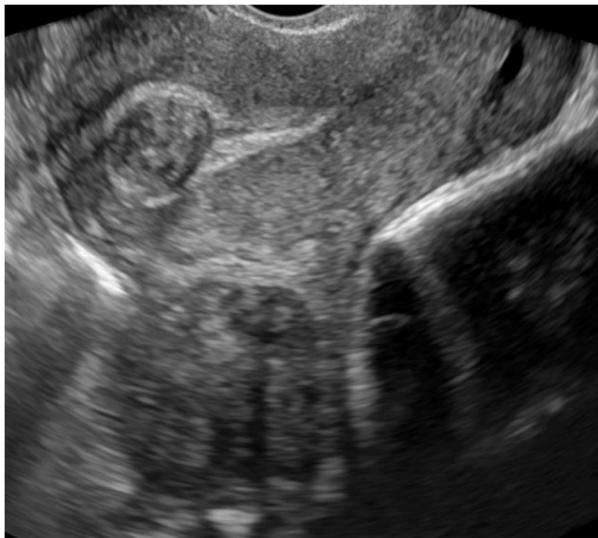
Uterine leiomyoma, intrauterine and subserosal-posterior uterus, by transvaginal pelvic ultrasound
